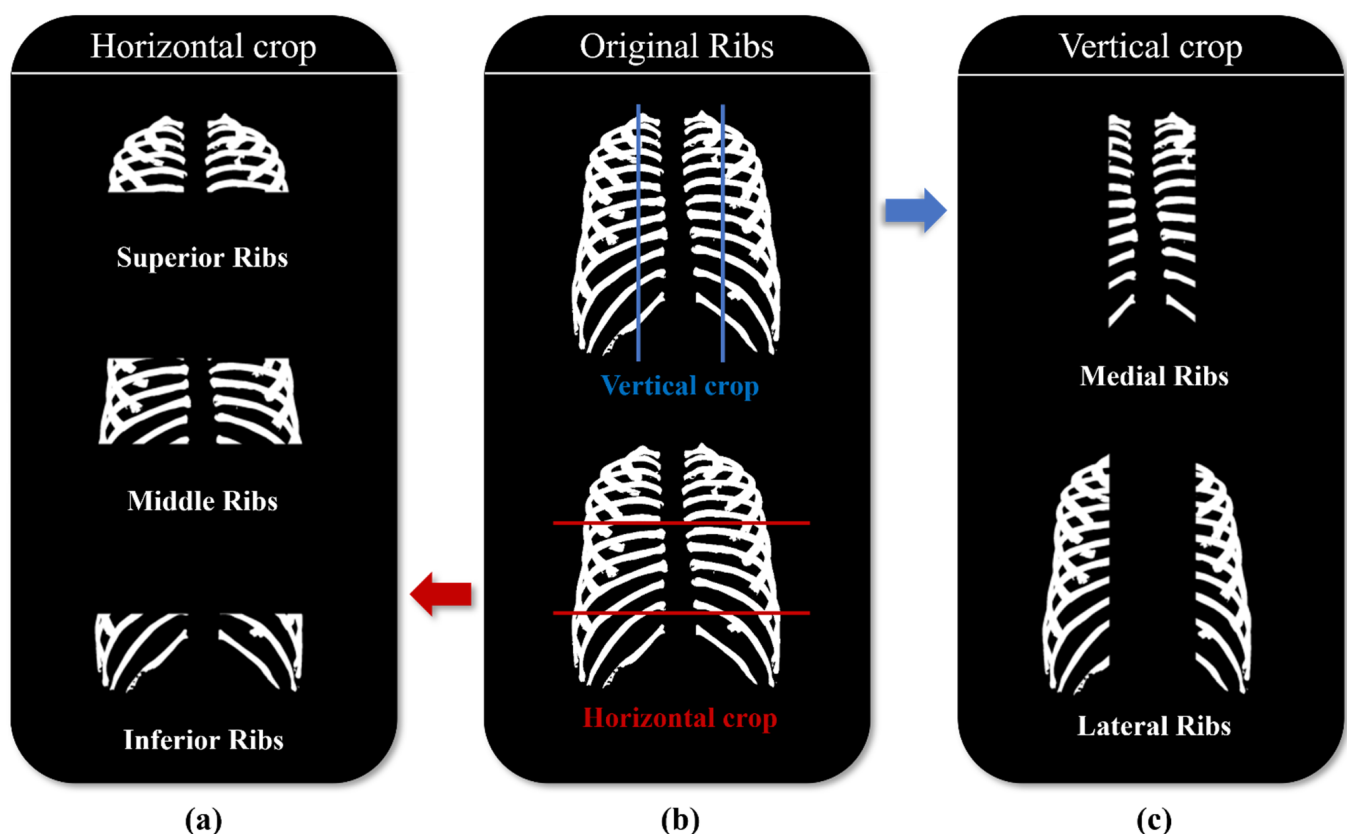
Criteria of dividing ribs: (a) Ribs vertically divide into medial and lateral of spine; (b) Original chest X-ray image; (c) Ribs horizontally divided into superior, middle, and inferior based on the clavicle, heart, and lower organs.
